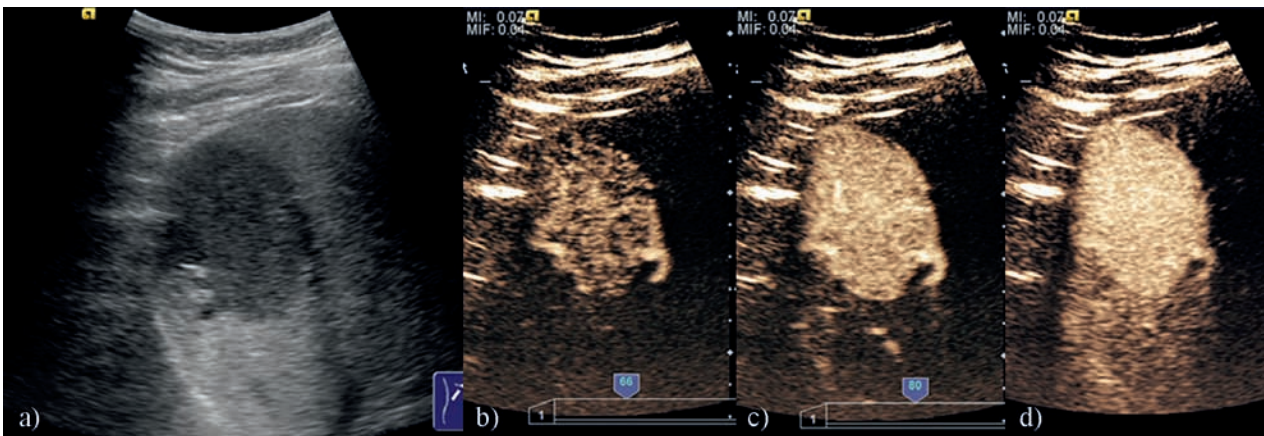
FNN – CEUS examination: a. Hypoechoic lesion in the right liver lobe at standard ultrasound; b. Arterial phase, 8 sec after injection – starting of the lesions' enhancement, visible feeding artery; c. Arterial phase, 9 sec after injection – rapid enhancement of the lesion d. Arterial phase, 12 sec after injection – Complete enhancement of the lesion
